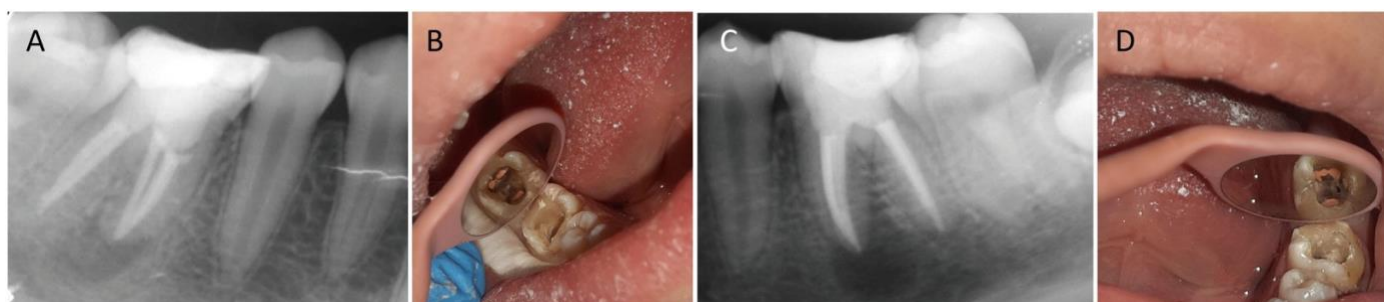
A post-operative radiograph. (A) after filling of tooth 46, (B) clinical view of tooth 46, (C) after filling of tooth 36, (D) clinical view of tooth 36.
